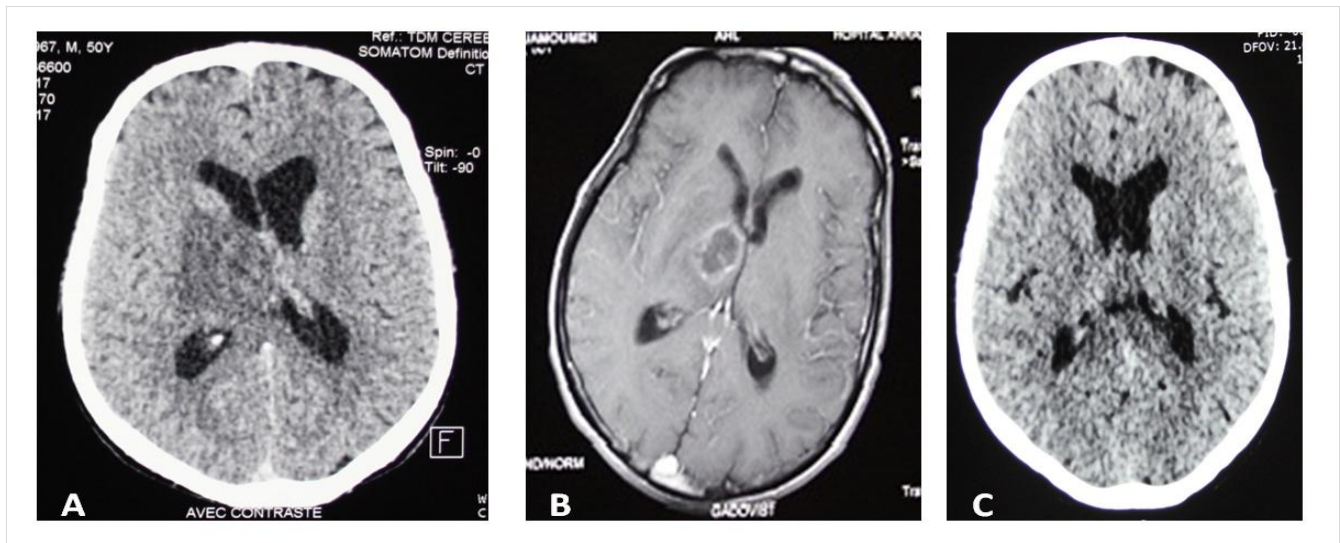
Radiographic Findings Before and After Therapy
